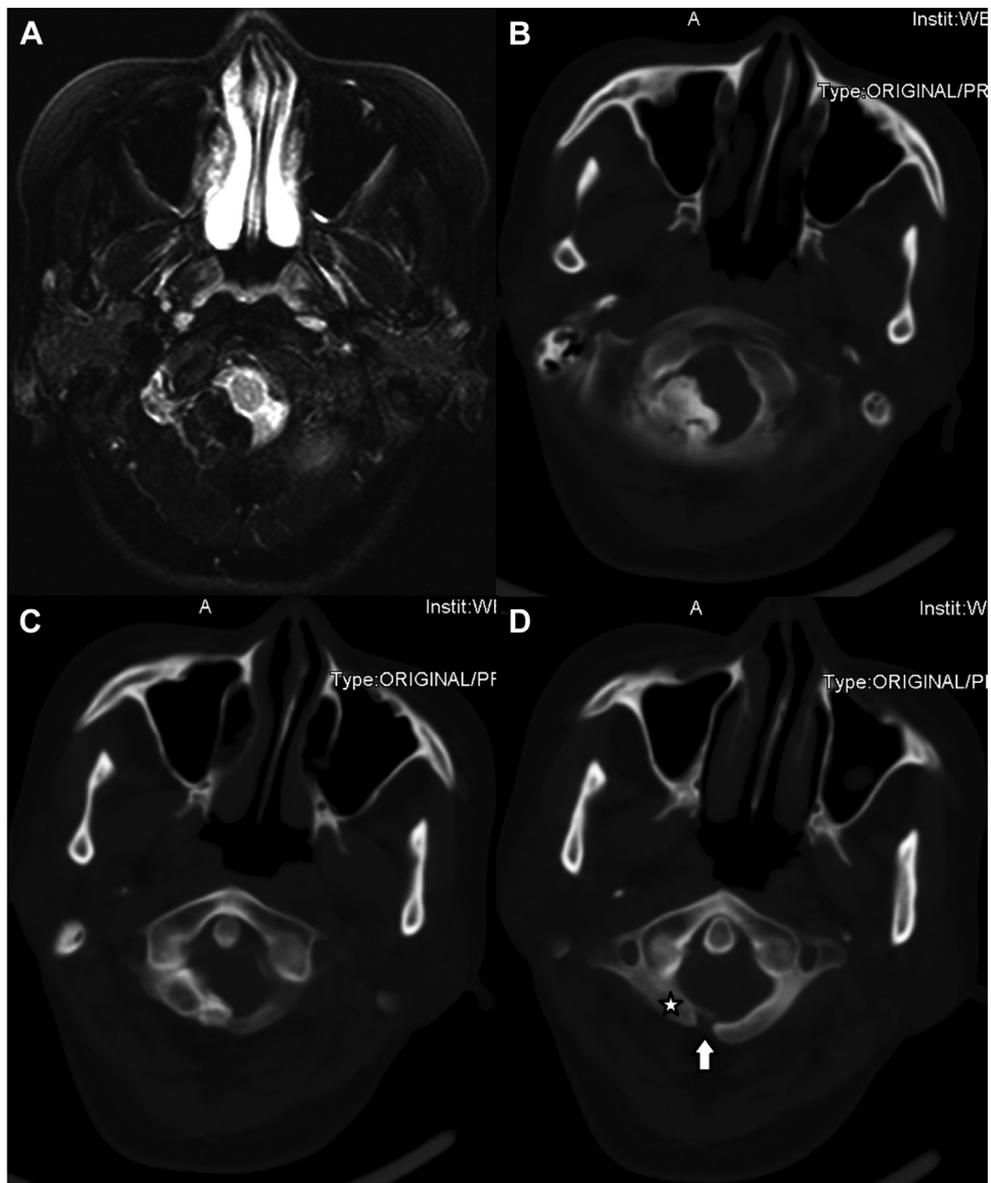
(A) Axial T2-weighted imaging of the craniocervical junction showing a hypertrophied squamous occipital bone with compression of the medulla and cerebellar tonsils; (B–D) serial axial computed tomography scans clearly demonstrating the hypertrophy of the squamous occipital bone and the posterior arch of the atlas (star) causing significant canal stenosis and a defect of the posterior arch of C1 (arrow).
